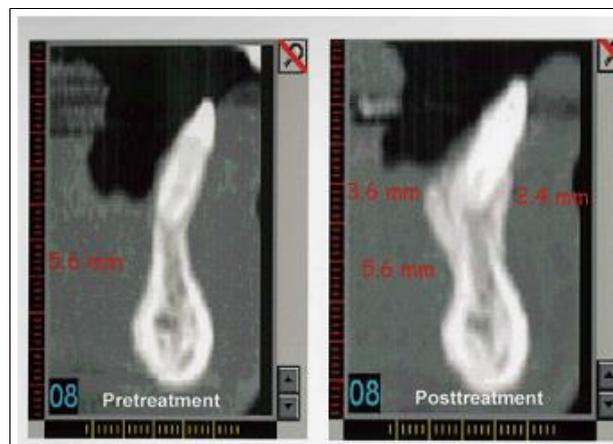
CBCT post grafting demonstrating 2.4mm of additional labial bone and 3.6mm of lingual bone at B point⁵³.
